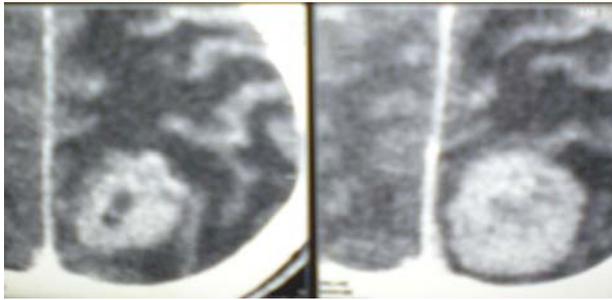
Computed tomography scan, contrast enhanced image, showing enhanced mass lesion with small cystic region in the centre with significant perifocal cerebral edema on left parietooccipital region.
